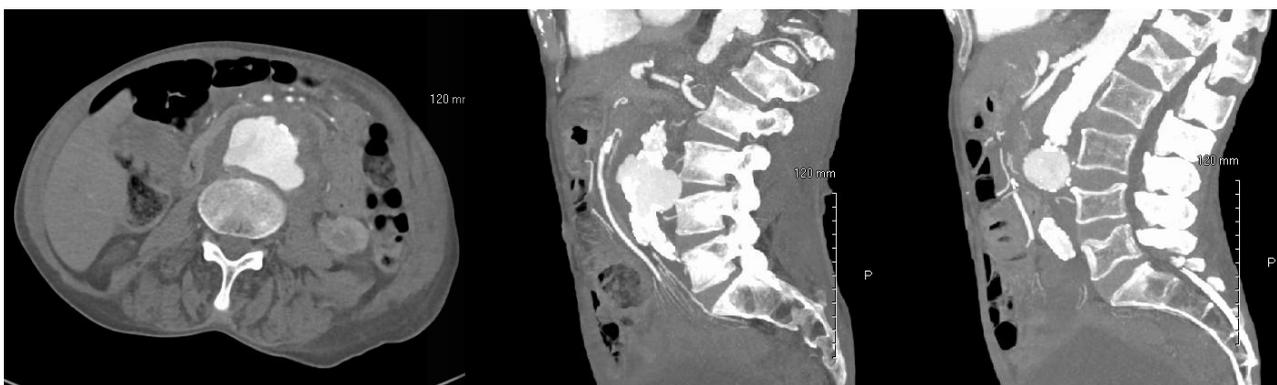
Follow up CT angiography done next day showed leaking mycotic aneurysm of distal abdominal aorta
